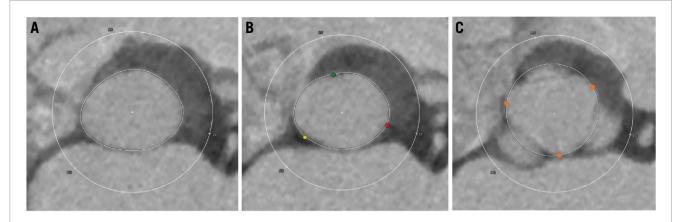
Multiplanar measurement in preprocedural CT. A) Left ventricular outflow tract and subannular plane measurements using standard techniques. B) Virtual annular plane measurement using the standard technique, defined by the plane connecting the three nadirs of the aortic sinuses (red dot: the nadir of the left coronary sinus; green dot: the nadir of the right coronary sinus; yellow dot: the nadir of the non-coronary sinus). C) Supra-annular plane measurement using a perfect circle defined by the three commissural points (orange dots). CT: computed tomography
